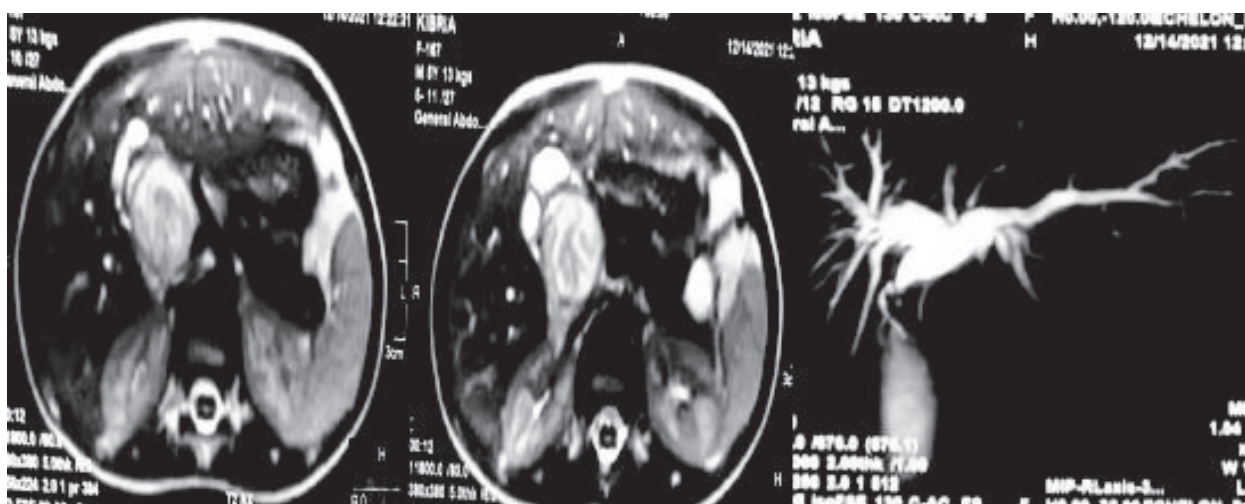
T2WI axial MRI scan & MIP image of MRCP showing an irregular oval shaped mass at the confluence of hepatic ducts with intrahepatic biliary dilatation.*
